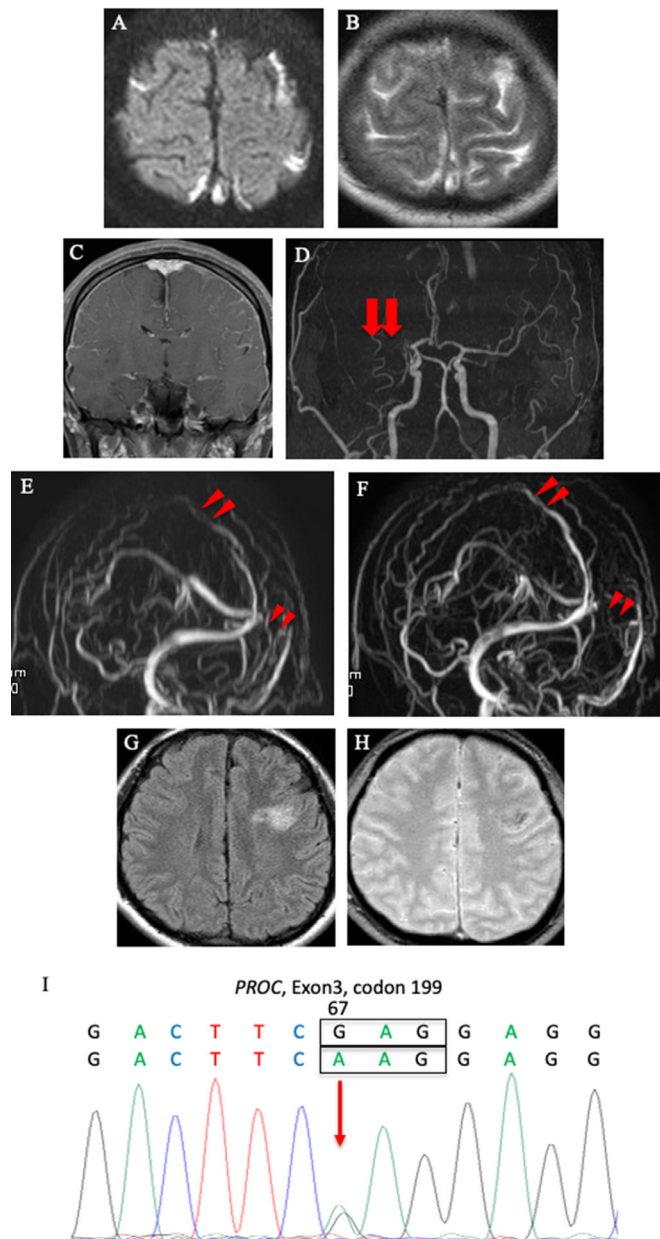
Brain magnetic resonance imaginings (MRI) (A-E on admission, F at day 20th and G and H at four months from first discharge) and a genetic analysis (I). (A) Diffusion-weighted imaging (DWI) demonstrated high intensities diffusely along the bilateral sulci. (B) Similar findings were found on fluid-attenuated inversion recovery (FLAIR) imaging. (C) Gadolinium contrast enhanced T1-WI demonstrated empty delta sign. (D) MR angiography showed chronic right middle cerebral artery occlusion (MCA) with collateral circulation (arrows). (E) MR venography revealed defect in the left transverse sinus and SSS (arrowheads). (F) Re-examination of MR venography showed improvement in the SSS blood flow but not in the left transverse sinus at day 20th (arrowheads). A new lesion appeared in the left frontal lobe with the edematous change and hemorrhagic change on FLAIR imaging (G) and T2* (H) at 2nd admission. (I) A genetic analysis revealed heterozygous mutation at exon 3c.199G>A, p.Glu67Lys on PROC.
